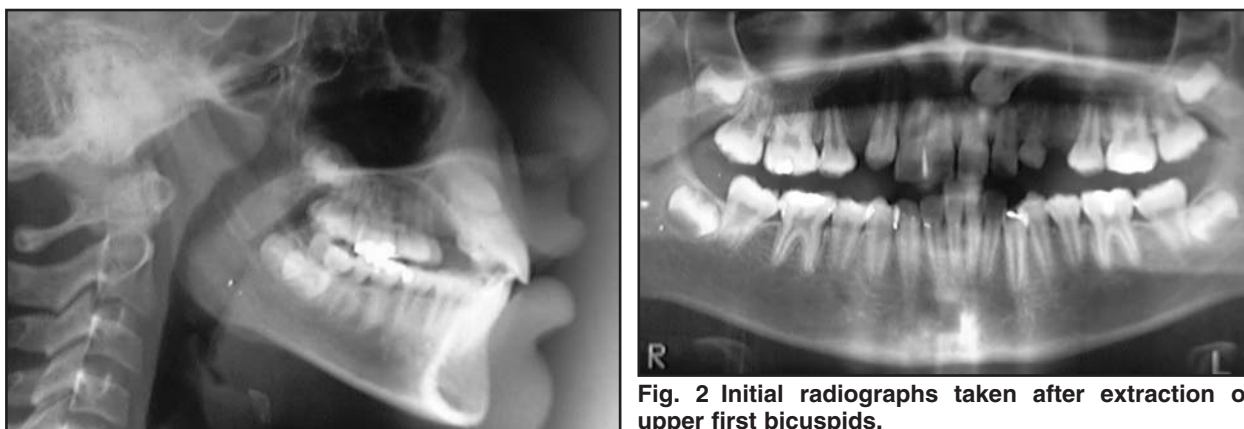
Initial radiographs taken after extraction of upper first bicuspids.
